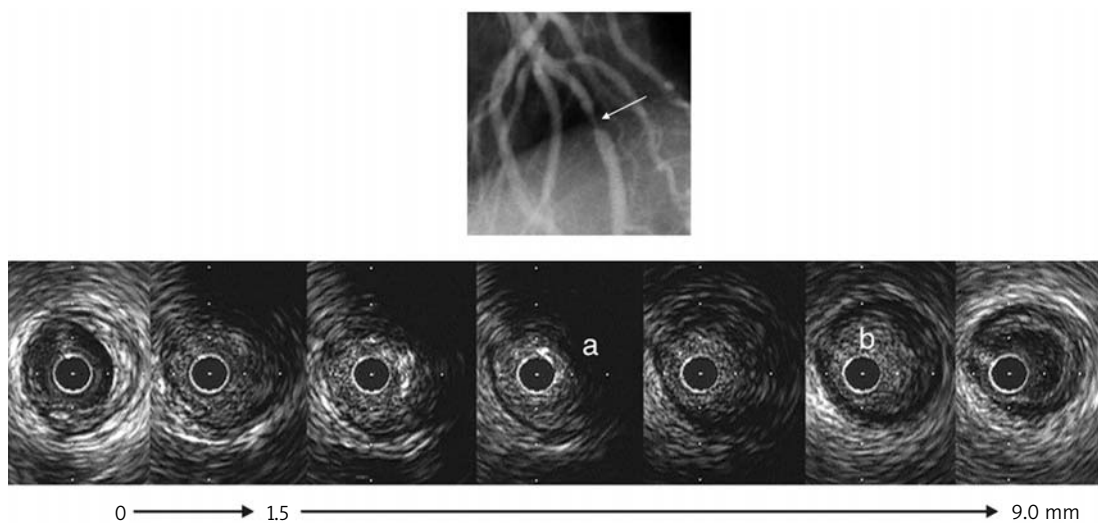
This patient presented with an evolving ST-elevation anterior myocardial infarction (white arrow in the angiogram). The IVUS study showed speckled plaque with attenuation (“a”) obliterating the lumen, but without the classical features of plaque rupture or thrombus formation. Note the blood stasis (“b”) distal to the occlusive lesion (from Mintz GS. Intracoronary Ultrasound. London, Taylor and Francis Group, 2005)
